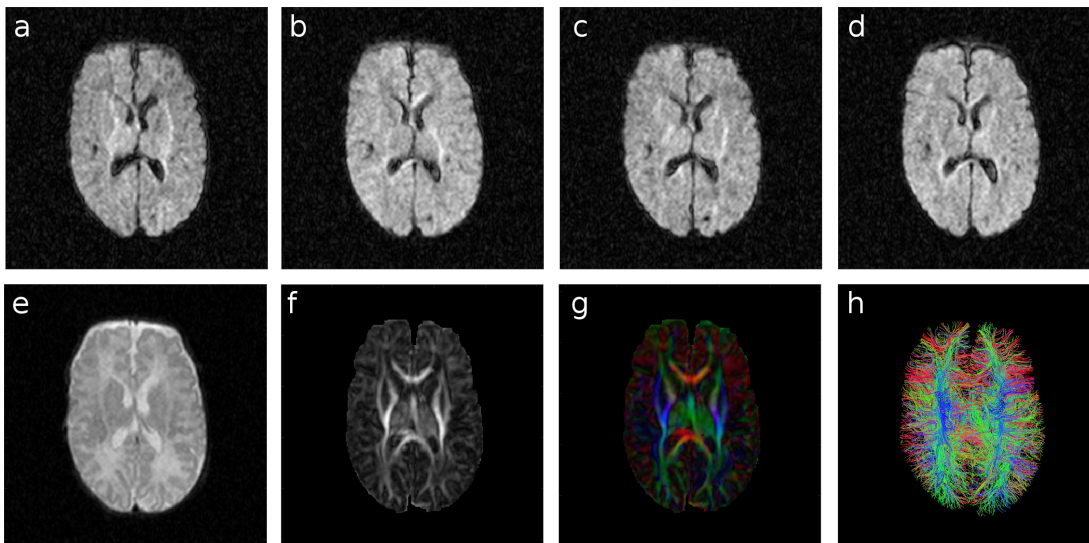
Axial slices of example scans of one representative preterm infant. a-b) Diffusion weighted images (DWI) for two gradient directions at $b = 600$, c-d) DWIs for two gradient directions at $b = 700$, d) a b_0 image (i.e., DWI with $b = 0$), e) FA map, f) map of primary modes of diffusion tensors, represented by colours (using the standard colour mapping), g) a sample of streamlines from tractography. Note that the SNR of the b_0 image is 34.9 dB where as the average SNR of the $b = 600$ and $b = 700$ images is 25.7 dB.
